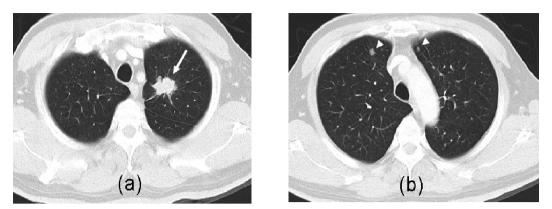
CT scan of the chest. (a) A speculated nodule (arrow) in the left upper lobe, $2.8 \text{ cm} \times 1.9 \text{ cm}$ in size. (b) Innumerable nodular lesions in both lungs (arrow heads).
